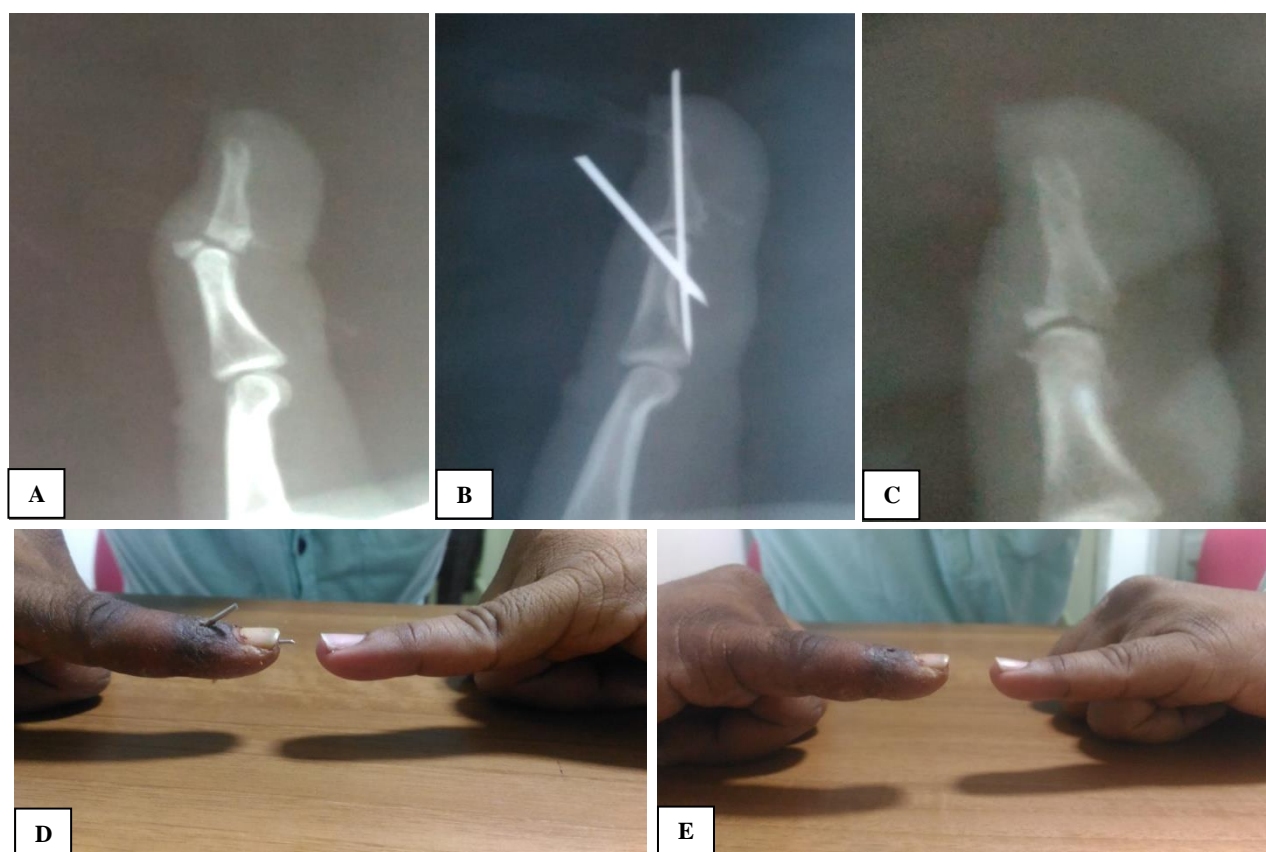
(A) Radiographs showing mallet fracture of the little finger; (B, C) Postoperative radiograph showing anatomical reduction of the fracture; (D) Clinical photograph of full extension of the DIP joint at 6 weeks follow up (E) Full extension maintained after wire removal (d).
